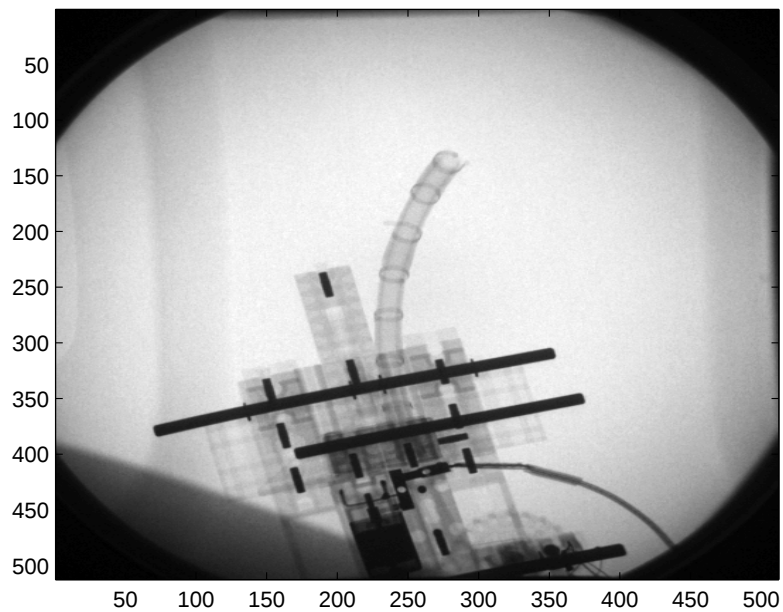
Metallic bars were used as wheels' axes to provide respiration markers in the acquired x-ray images.
